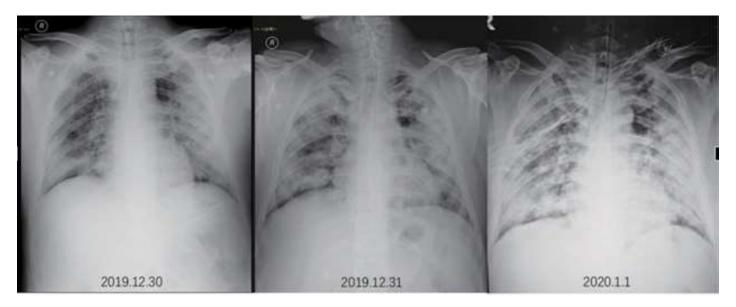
Chest X-ray for daily progression monitoring
